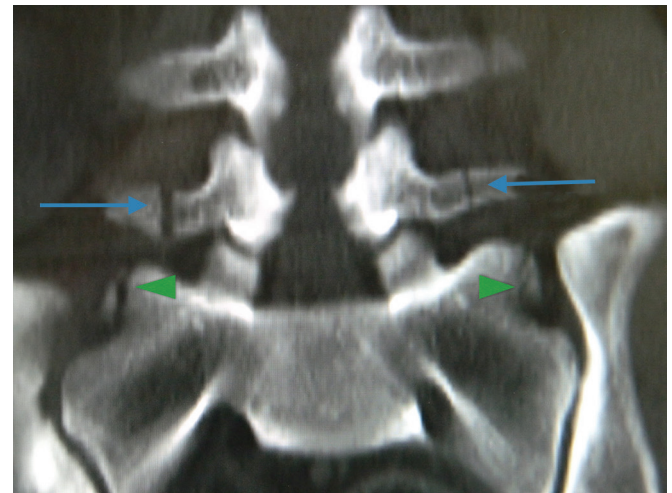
The CT coronal image showing bilateral L5 transverse process (*long arrows*) and bilateral alar chip fractures (*short arrows*)
